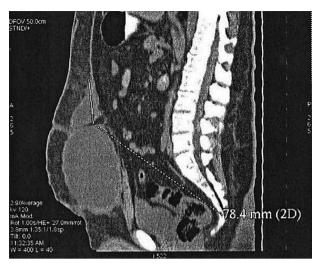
Multi-slice computed tomography of the abdomen, sagittal plane: liquid collection between fascia and subcutaneous fat tissue of the abdominal wall (line).
